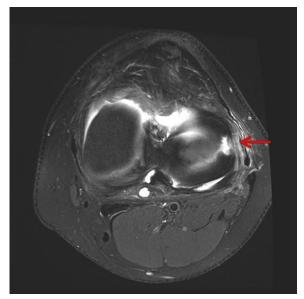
T2-weighted axial image of the left knee showing a large radial tear of the midbody of the lateral meniscus (arrow).
